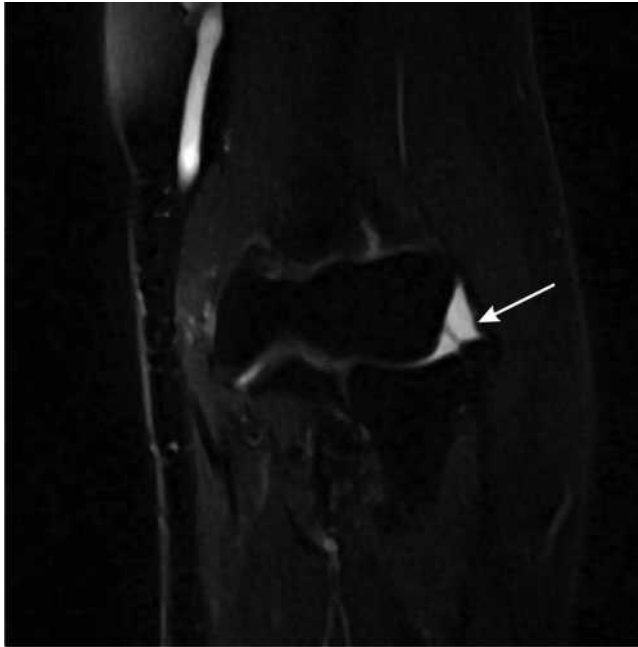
Lateral epicondylitis. T_2 weighted MRI of the elbow showing a partial thickness tear of the common extensor tendon (arrow).
